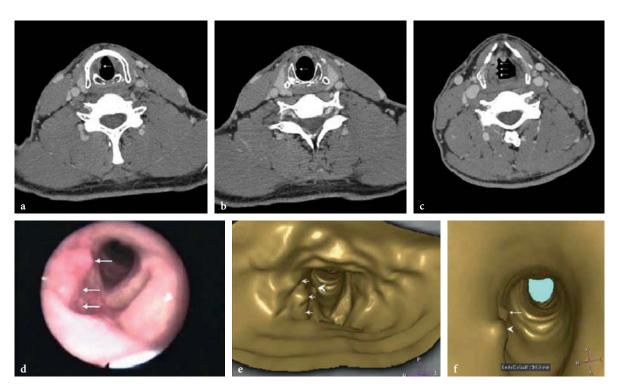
Transverse CT images (a–c) show multifocal carcinoma (arrows) involving the right vocal cord (a), and the right side of the subglottic (b) and supraglottic space (c). OE image (d) showing the right glottic-supraglottic tumor (arrows). VL images showing the right vocal cord lesion (arrowhead in e,f), the right supraglottic lesion (e, arrows), and the right subglottic lesion (f, arrow). Reprint with permission granted by Men S et al. Diagnostic contribution of virtual endoscopy in diseases of the upper airways. In: J Digit Imaging, Springer, Berlin Heidelberg New York, 2006:1–5
